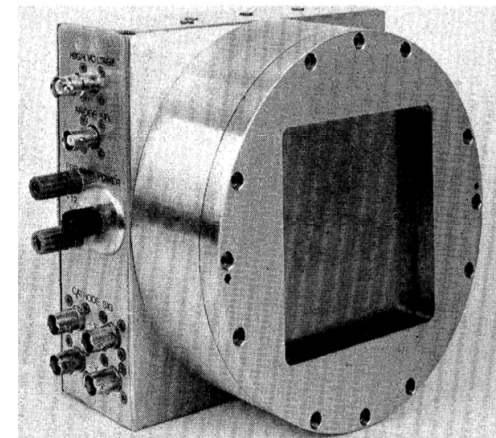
Electronic position-sensitive x-ray detector. [Courtesy of Xentronics Company, Inc., Cambridge, Massachusetts]
